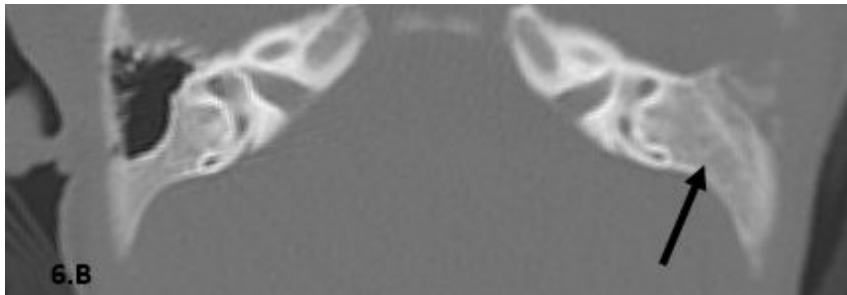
B: Axial CT view, bone window revealed agenesia of the left mastoid air cells (black arrow).
